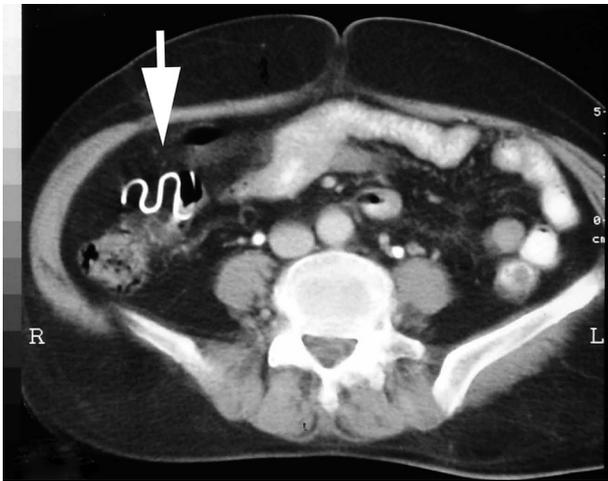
CT scan demonstrated radiopaque wandering IUD at right lower abdomen. No bowel obstruction or intra-abdominal abscess was seen.
